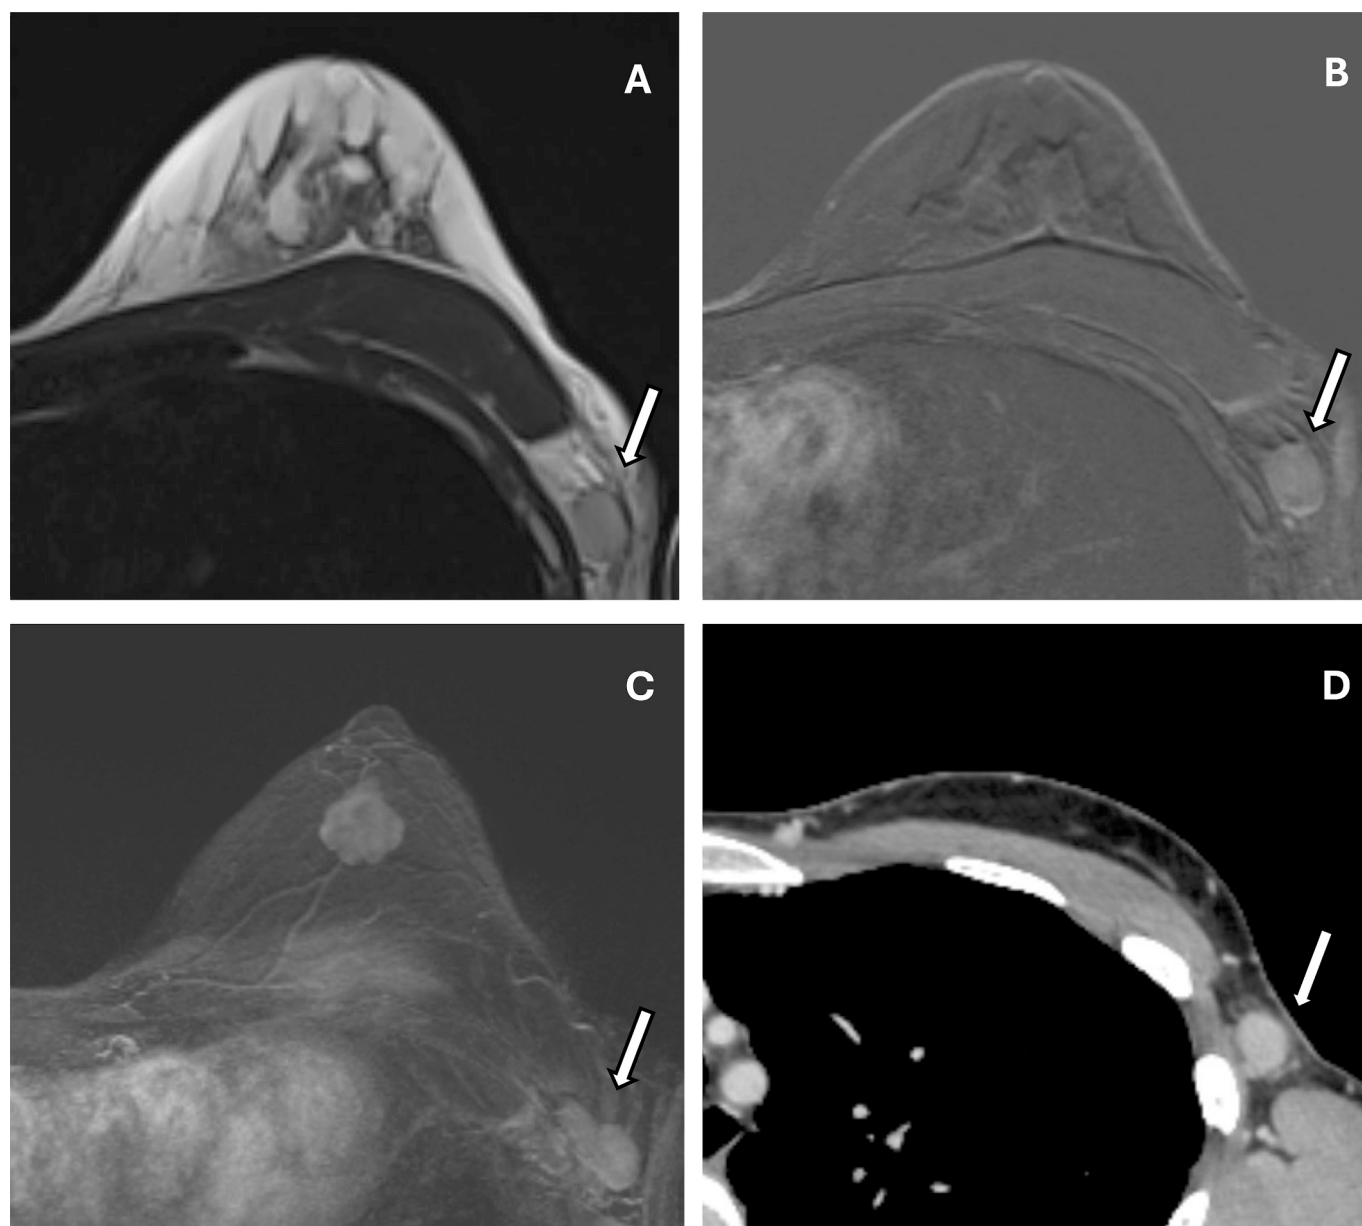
Node-RADS MRI vs CT* – 39-year-old woman with unifocal grade 2 breast carcinoma of no special type (IBC-NST) in the left breast undergoing preoperative MRI and CT staging. (A) Axial T2-weighted image shows a spherical, enlarged lymph node with smooth borders, without fatty hilum (arrow); (B, C) Axial contrast-enhanced T1-weighted image and MIP projection show homogeneous enhancement (arrow). These features are consistent with Node-RADS 3. (D) Axial venous phase shows the same features as above, but enhance the irregular border, upgrading Node-RADS score from 3 to 4.
